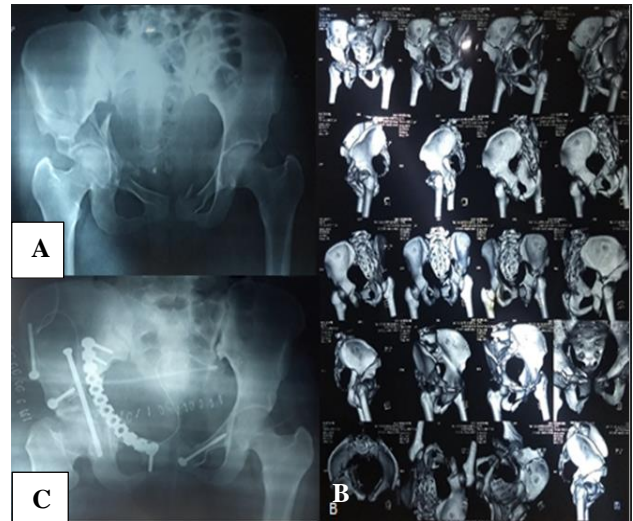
24-year-old female right sided ACPHT fracture (A) pre-op X-ray; (B) pre-op CT scan; (C) immediate post-op X-ray.
